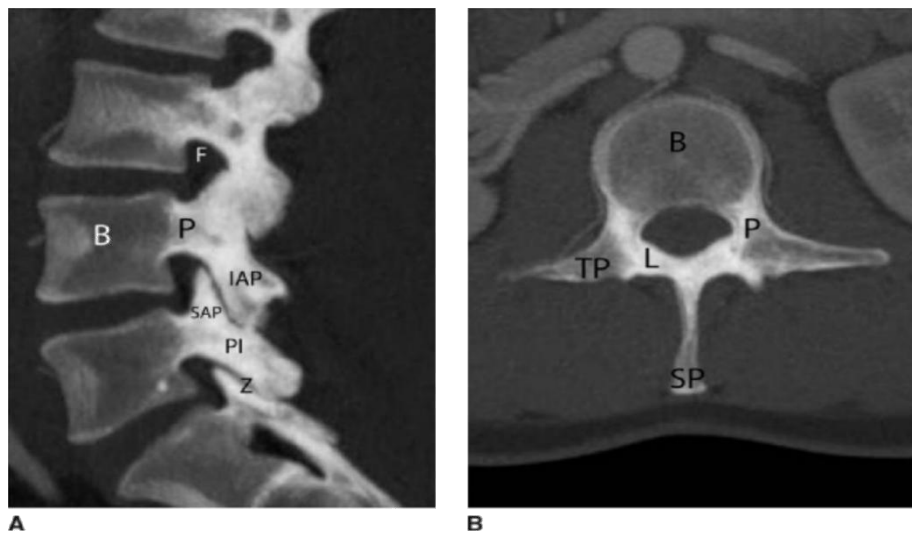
A: Sagittal CT MIP of the lumbar spine demonstrating the vertebral body (B), pedicle (P), superior articular process (SAP), inferior articular process (IAP), and zygapophyseal joint (Z). The superior articular processes extend superiorly from the junction of the laminae and pedicles, while the inferior articular processes extend inferiorly from the undersurface of each lamina. The zygapophyseal joints are formed by the superior articular facet and the inferior articular facet. The pars interarticularis (PI) is the portion of the lamina between the superior and inferior articular processes. The intervertebral foramen (F) allows for the passage of spinal nerves and vessels. :Axial CT MIP of the lumbar spine demonstrating the vertebral body (B) and posterior neural arch. (P,pedicle; TP, transverse proocess; L, lamina; SP, spinous process).
